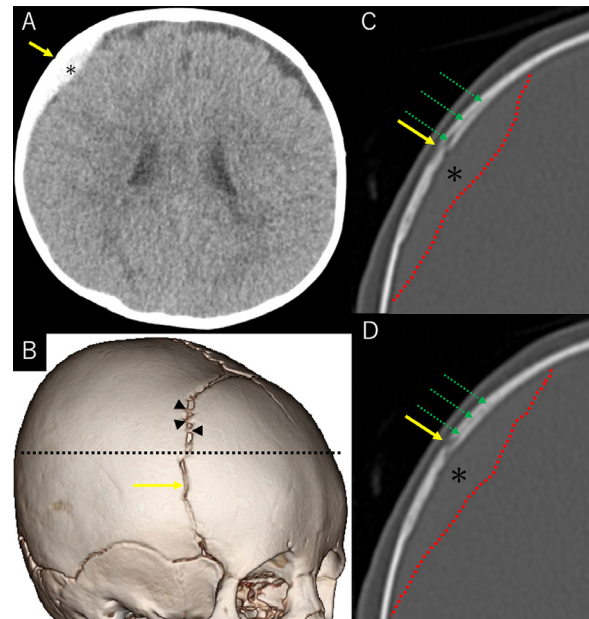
(A) Axial computed tomography (CT) at the level of scalp discoloration showing an intracranial hematoma below the coronal suture (arrow), slightly compressing the right frontal lobe (asterisk). (B) Three-dimensional CT shows many bony bridges in the coronal suture connecting the frontal and parietal bone (arrowheads). (C, D) Contiguous magnified images of bone-target axial CT at the level of scalp discoloration, showing a linear crack formed in the diploic of the frontal bone (dotted arrows) contacting the coronal suture (arrow). Note that the intracranial hematoma (asterisk) has maximal thickness just below the scalp discoloration. The dotted line in B: scanned level of A, C, and D; Dotted line in C and D: lower margin of the hematoma.
